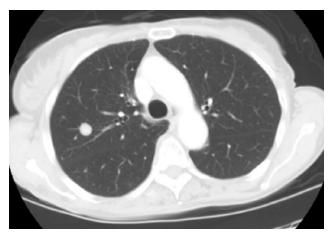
Chest computed tomography scan with contrast shows numerous indeterminate pulmonary nodules, with the largest, in the right upper lobe, measuring 1.2×1.3 cm.
